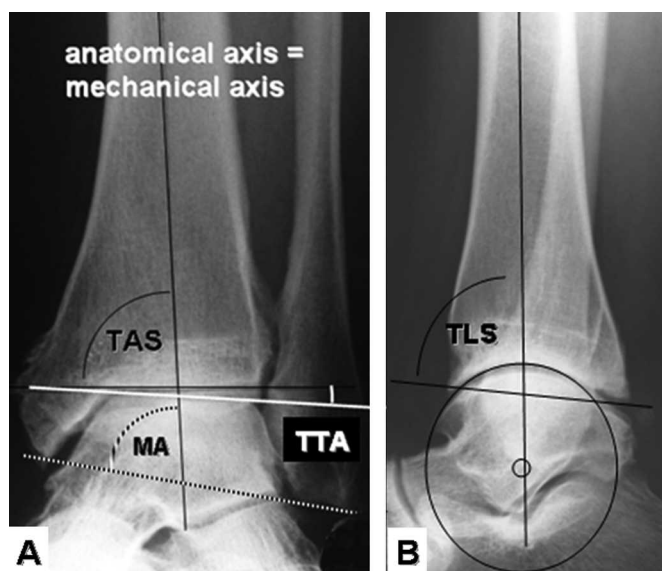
The ankle sector of weightbearing radiographs of the lower leg shows angles around the ankle used to analyze asymmetric ankle OA. (A) In normal knees and hips, the anatomic axis of the tibia runs parallel to the mechanical axis of the leg. Ankle misalignment was analyzed in the frontal plane with the tibial anterior surface angle (TAS), the tibiotalar tilt angle (TTA), and the malleolar angle (MA). (B) In the sagittal plane, the tibial lateral surface angle (TLS) was measured. The small circle marks the center of rotation of the joint, which normally is located in line with the anatomic tibial axis.
